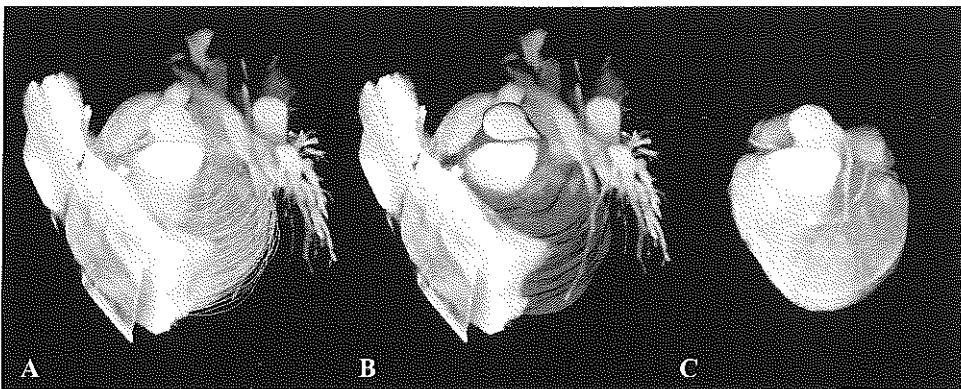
Image segmentation has to be performed before volume rendering can take place. The magnetic resonance images are obtained with a respiratory-gated three-dimensional gradient echo technique. Resolution 1.9 mm × 1.25 mm × 2 mm. (A) On all slices of a data set contours are drawn to select the desired structures. (B) From these contours a subvolume is created automatically. (C) The structures that are not selected are removed, so that the coronary arteries can be analysed without obstruction.
